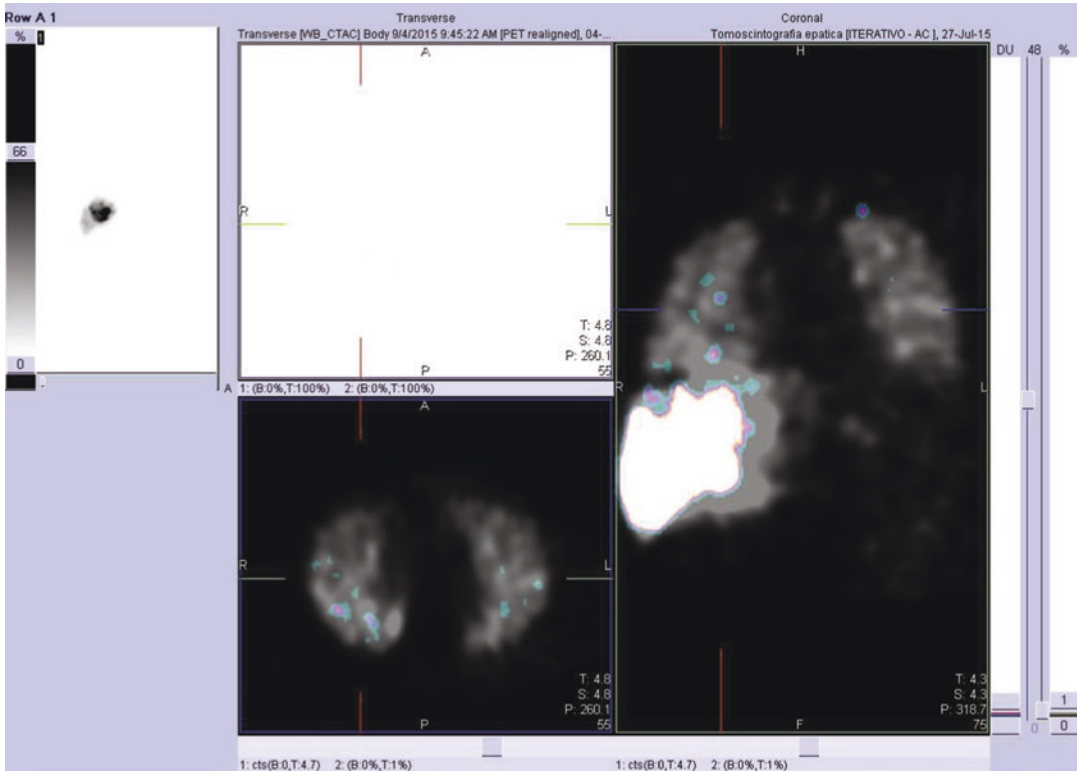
Example of overestimation of lung shunt in ^{99m}Tc -MAA SPECT (in gray level) compared to ^{90}Y PET (color)
